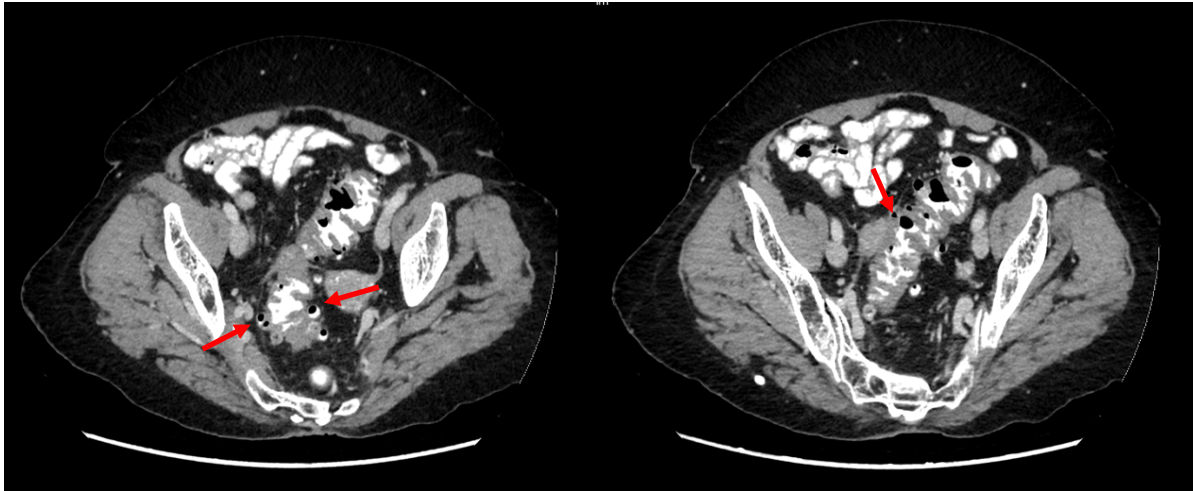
Post-contrast axial CT scan of the pelvis shows multiple diverticula (arrow) are seen along the sigmoid colon associated with circumferential sigmoid wall thickening
